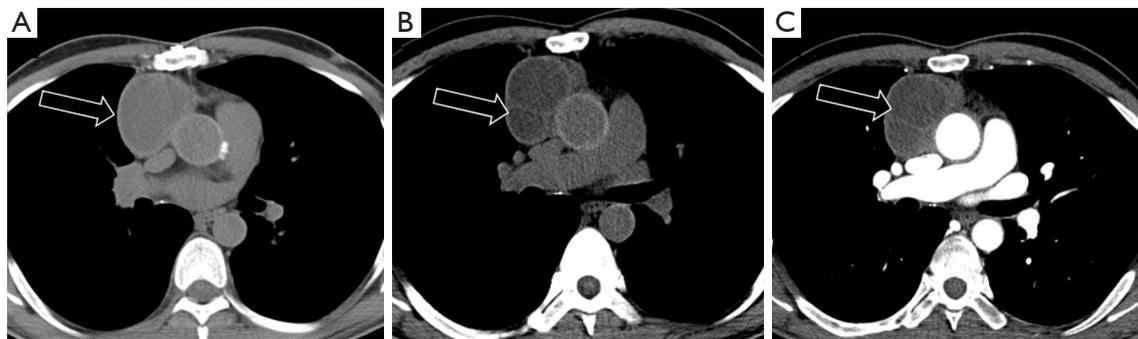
61-year-old male with a cystic thymoma. CT imaging demonstrates a well-circumscribed cystic lesion with minimal peripheral enhancement (A, black arrow). Thick internal septations (B, black arrow) that do not demonstrate definite enhancement (C, black arrow) are present. This is one such example in which MRI imaging would provide useful information to assess for an underlying solid mass or enhancing nodularity to corroborate cystic neoplasm. CT, computed tomography; MRI, magnetic resonance imaging.
